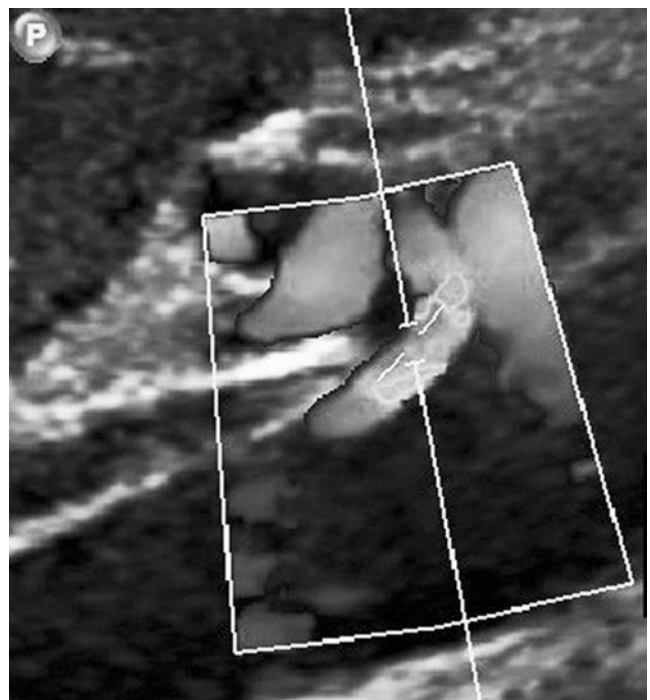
Ultrasound velocities were augmented to >300 cm/s upon inspiration. (Republished with permission of Lainez RA, Richardson WS. *Ochsner J.* 2013;13(4):561–4.²³)
